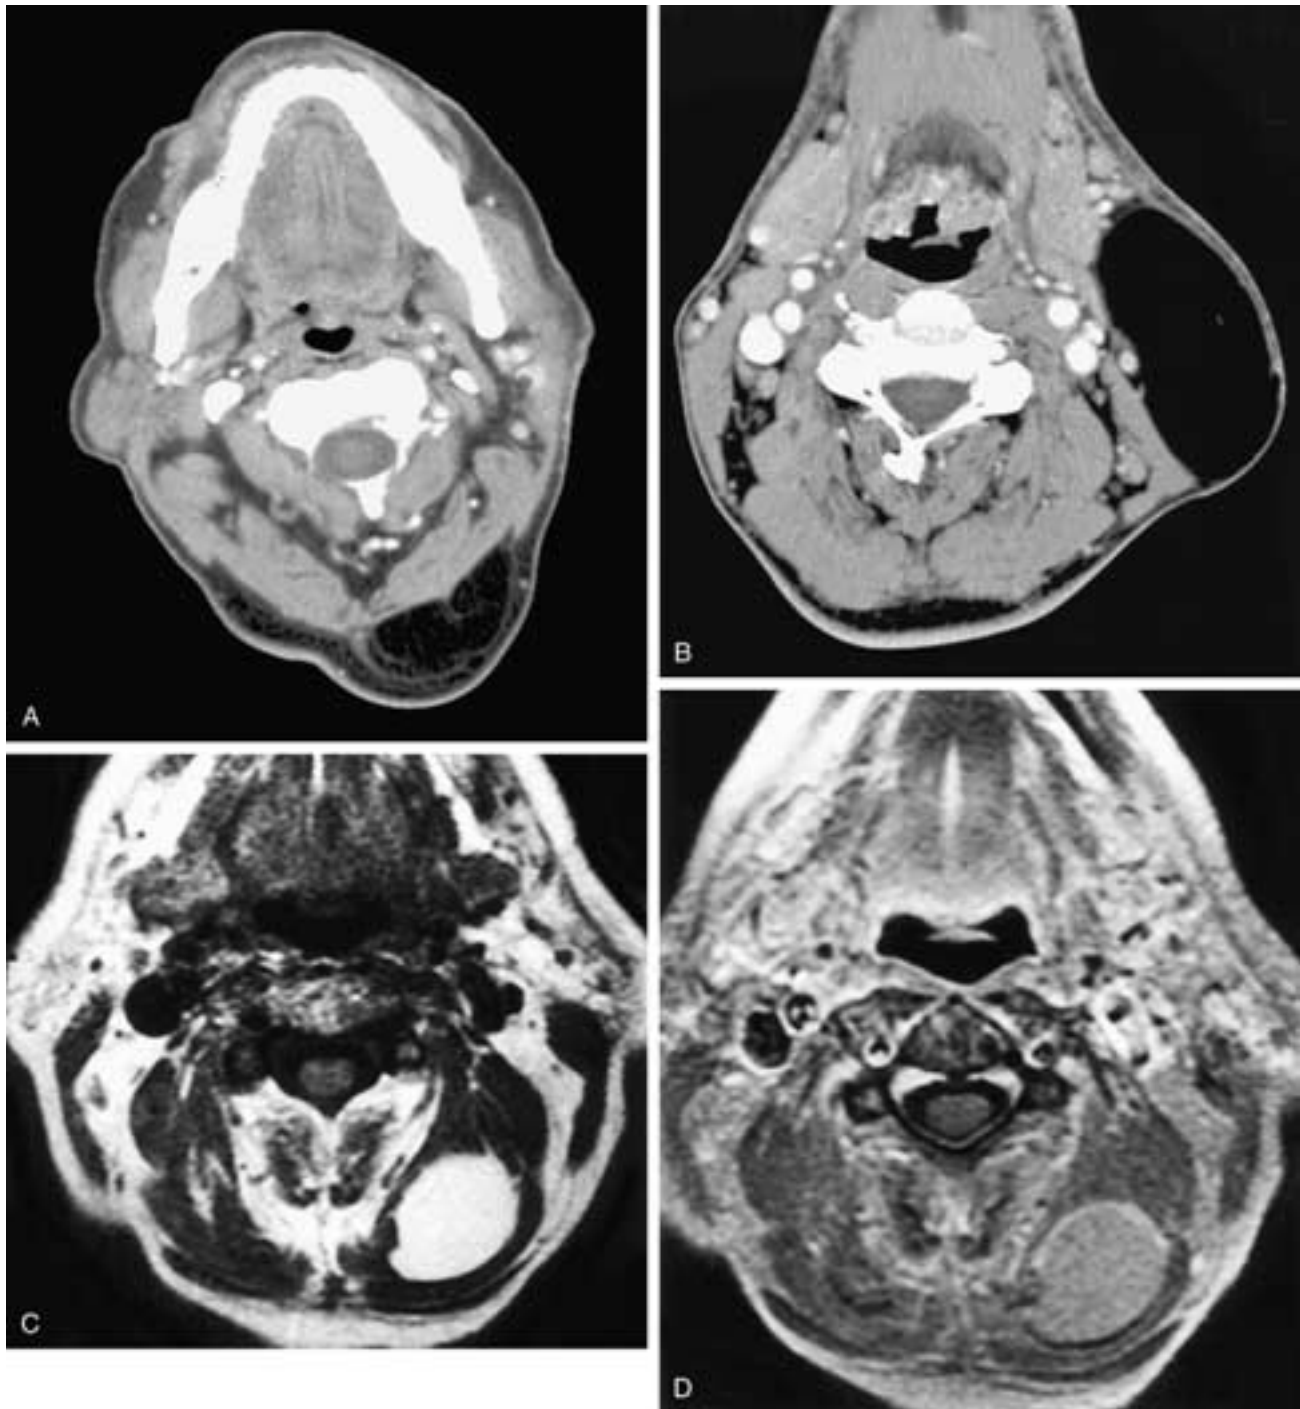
A, Axial contrast-enhanced CT scan shows a well-delineated fatty mass in the subcutaneous tissues of the back of the neck. B, Axial contrast-enhanced CT scan shows a well-delineated fatty mass in the subcutaneous tissues of the left neck. Despite the size of the mass, there are smooth, noninfiltrating borders. Axial T1-weighted image (C) shows a well-circumscribed high signal intensity mass situated between the left paraspinal muscles. The lesion is isointense to normal fat. D, Axial T1-weighted, fat-suppressed, contrast-enhanced MR image shows that the mass suppresses like normal fat. All of these patients had ordinary lipomas.
